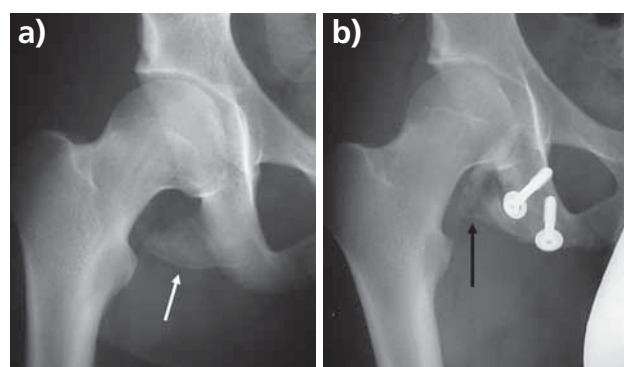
a) Avulsion fracture of the ischial tuber and its dislocation in a 15-year-old football player (white arrow). b) X-ray six months after surgical fixation of the avulsed fragment with screws. Post-traumatic ossification in the injured area (black arrow).
